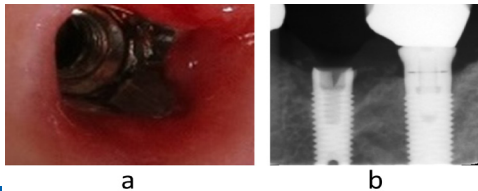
Implant fracture with platform wall separation: clinical (a) and radiographic (b) view.
